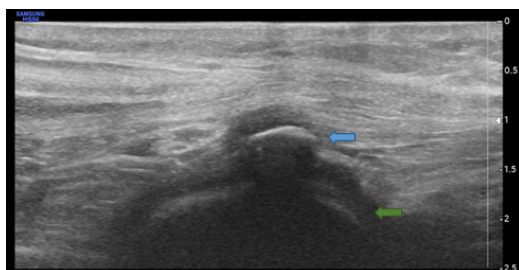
Ultrasound image of right knee (sagittal prone view). Blue arrow shows the fabella. Green arrow shows de femoral condyle.
